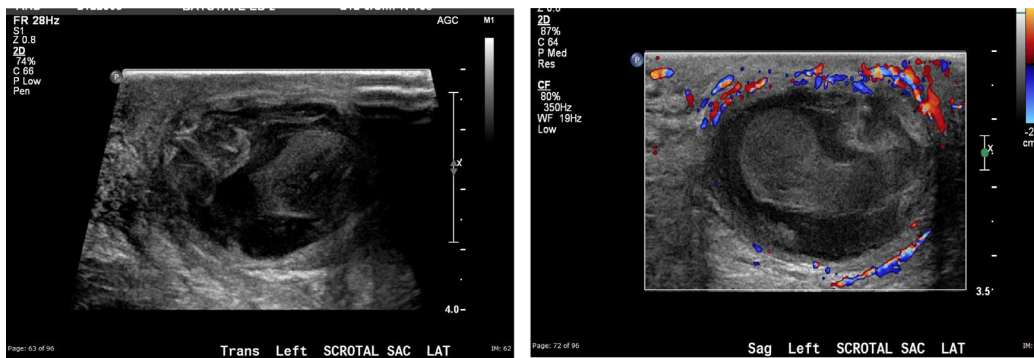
Scrotal abscess: large heterogeneous scrotal collection, with no internal flow on color Doppler assessment. (Color version of figure is available online.)
